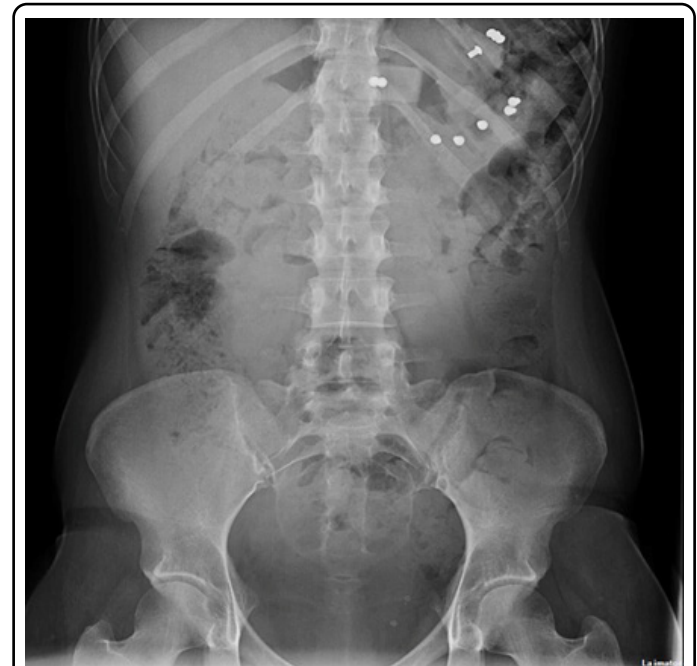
Abdominal X-ray where various foreign bodies are observed.
